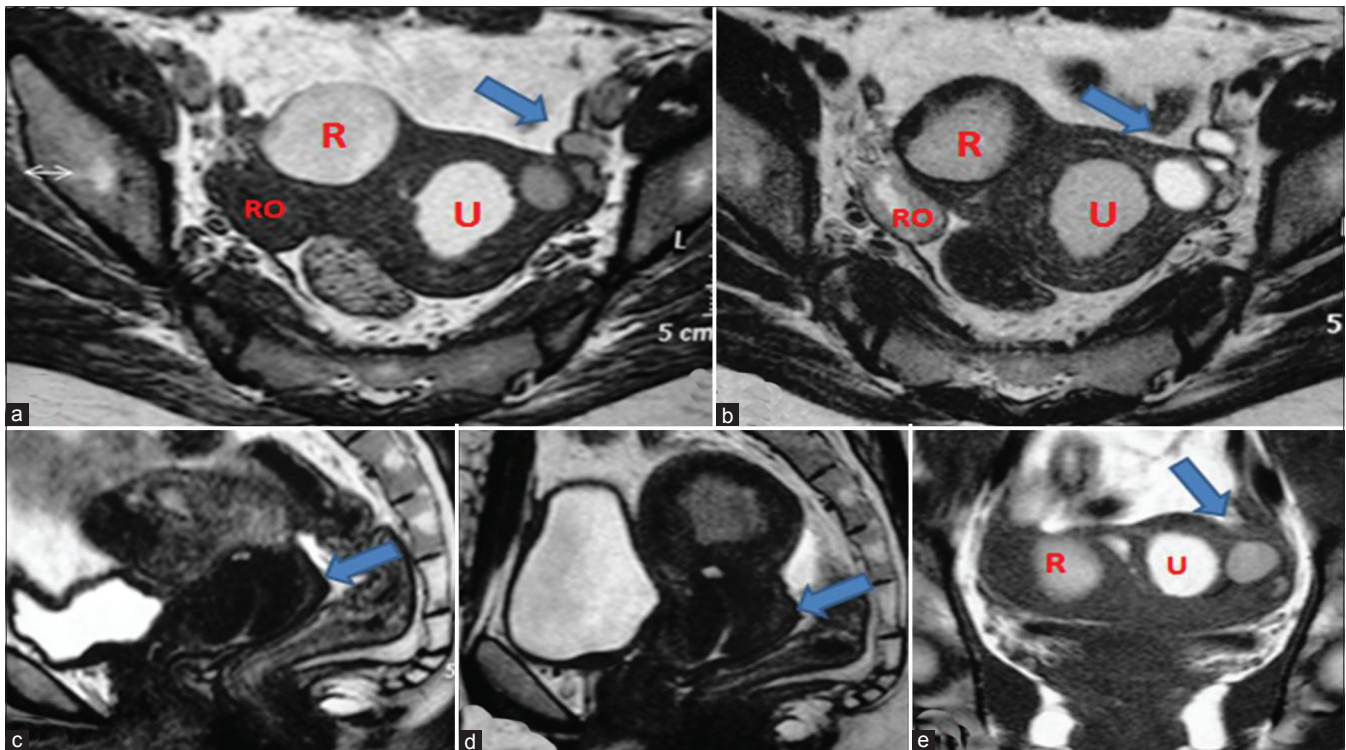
Magnetic resonance imaging of pelvis. Axial T1W (a) and T2W (b) Images showing unicornuate uterus (U) with rudimentary right horn (R). Both cavities are filled with blood (hyperintense on T1W and T2W images). There is left hematosalpinx with dilated, blood filled fallopian tube (arrow). Normal right ovary (RO) seen. Sagittal T2W images (c, d) Showing well formed cervix (arrow) with no communication between endometrial cavity and endocervical canal. Coronal T1W image (e) Showing hematometra in unicornuate uterus (U) and rudimentary horn (R) with left hematosalpinx (arrow)
